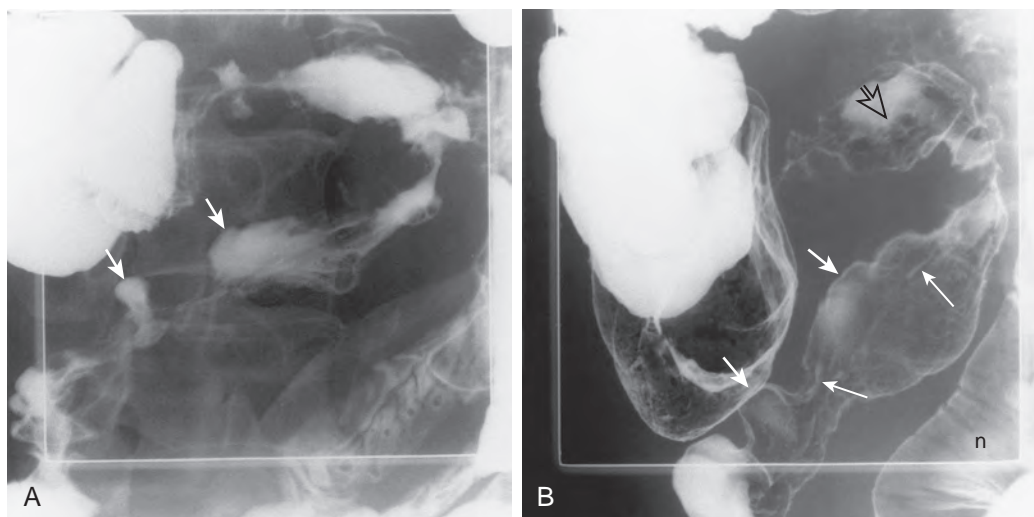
Peroral pneumocolon in a patient with suspected Crohn's disease. A. Spot radiograph from small bowel follow-through shows an abnormal terminal ileum, manifested by sacculations (*arrows*) alternating with areas of narrowing. B. Spot image from peroral pneumocolon shows that most of the areas of narrowing are more distensible than shown in A. Several mesenteric border ulcers (*long arrows*) and sacculations (*short arrows*) characteristic of Crohn's disease are now visualized. The mucosa is focally nodular (*open arrow*). Compare and contrast the appearance of the mucosa in the terminal ileum with that in an adjacent loop of normal ileum (*n*).
